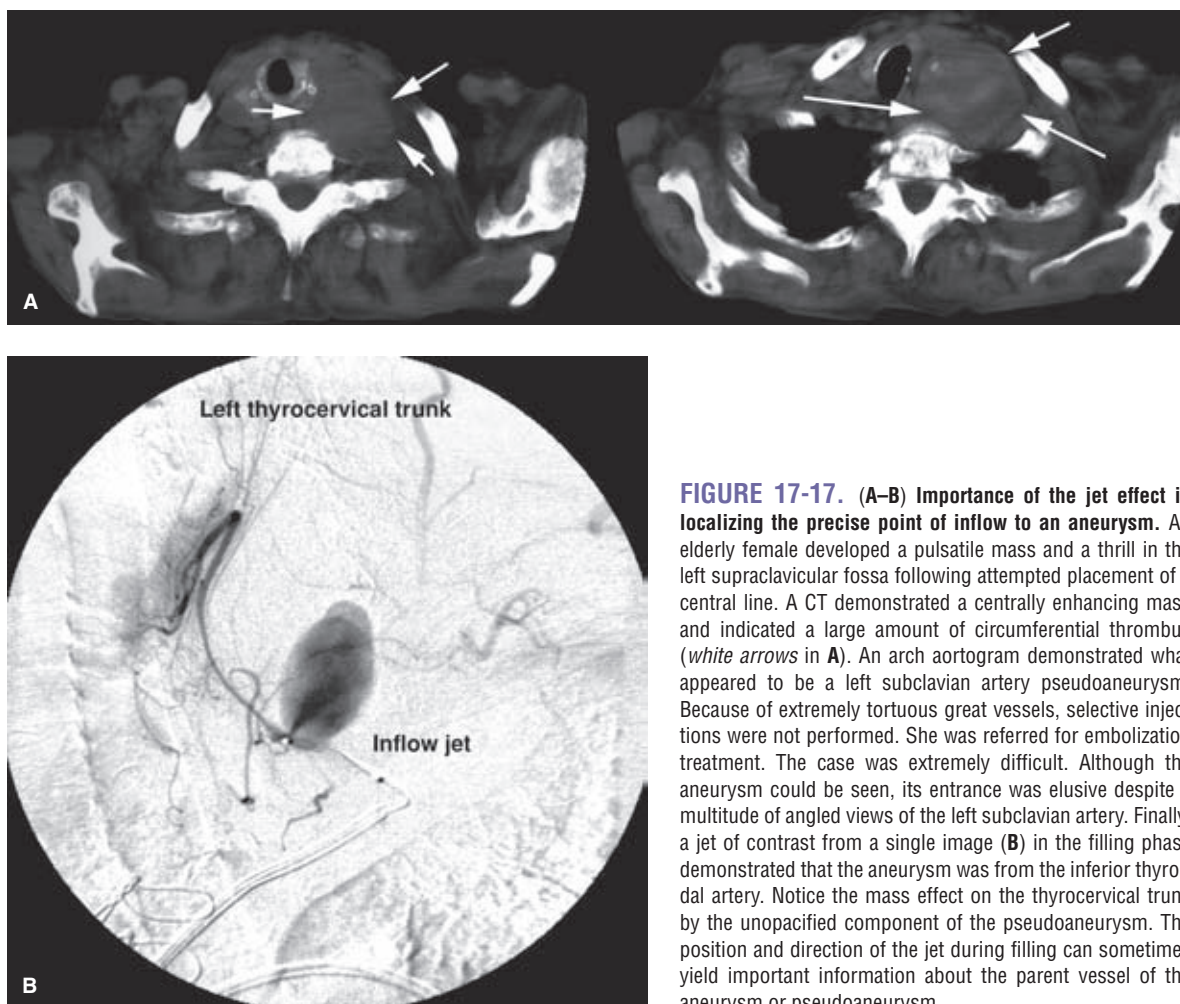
(A–B) Importance of the jet effect in localizing the precise point of inflow to an aneurysm. An elderly female developed a pulsatile mass and a thrill in the left supraclavicular fossa following attempted placement of a central line. A CT demonstrated a centrally enhancing mass and indicated a large amount of circumferential thrombus (*white arrows in A*). An arch aortogram demonstrated what appeared to be a left subclavian artery pseudoaneurysm. Because of extremely tortuous great vessels, selective injections were not performed. She was referred for embolization treatment. The case was extremely difficult. Although the aneurysm could be seen, its entrance was elusive despite a multitude of angled views of the left subclavian artery. Finally, a jet of contrast from a single image (*B*) in the filling phase demonstrated that the aneurysm was from the inferior thyroidal artery. Notice the mass effect on the thyrocervical trunk by the unopacified component of the pseudoaneurysm. The position and direction of the jet during filling can sometimes yield important information about the parent vessel of the aneurysm or pseudoaneurysm.
